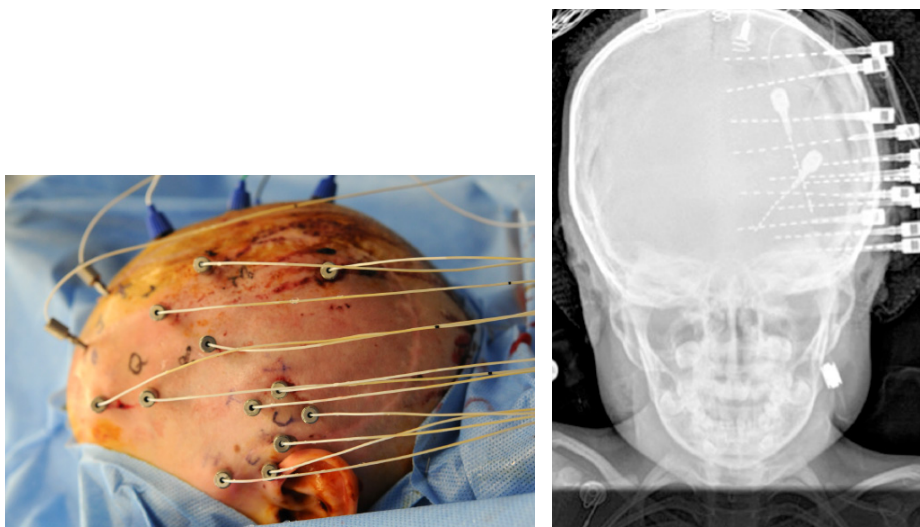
Patient at the end of the procedure, after the implantation of depth electrodes and skull X-ray with the positioning of the electrodes [14]
